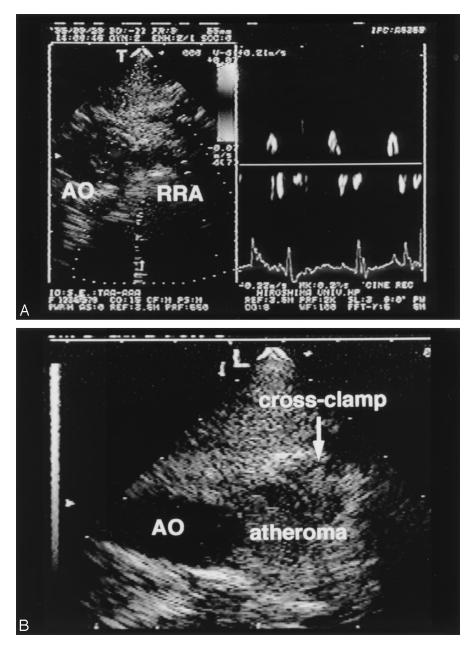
Echocardiograms demonstrating (A) to-and-fro pattern of blood flow in the right renal artery after crossclamping of the aorta and (B) atheroma that fills the aortic lumen in case 7. AO, Aorta; RRA, right renal artery.
